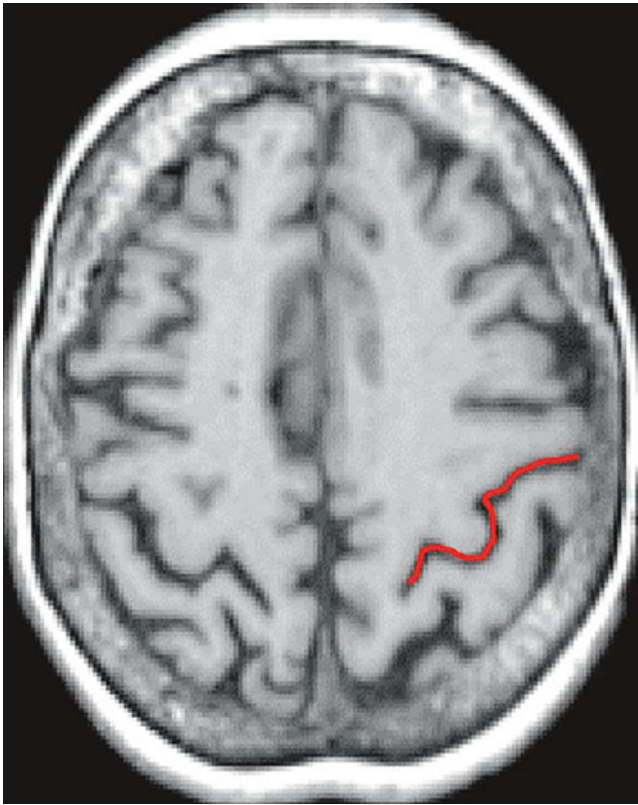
MRI showing the central sulcus and the precentral gyrus
